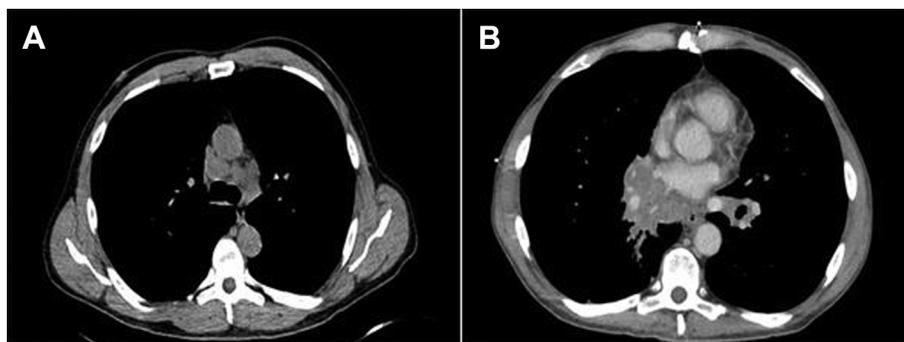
A, Lung cancer screening CT scan showing enlarged paratracheal lymph nodes. No lung nodules are present. B, Chest CT scan when patient presented 6 months later with pneumonia. Large right hilar mass is evident. Biopsy results confirmed large-cell lung cancer.
